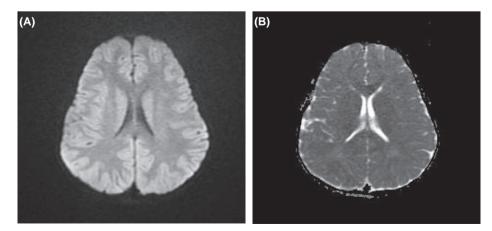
Follow-up DWI (A) and ADC map (B) obtained one month later did not show the lesion.
